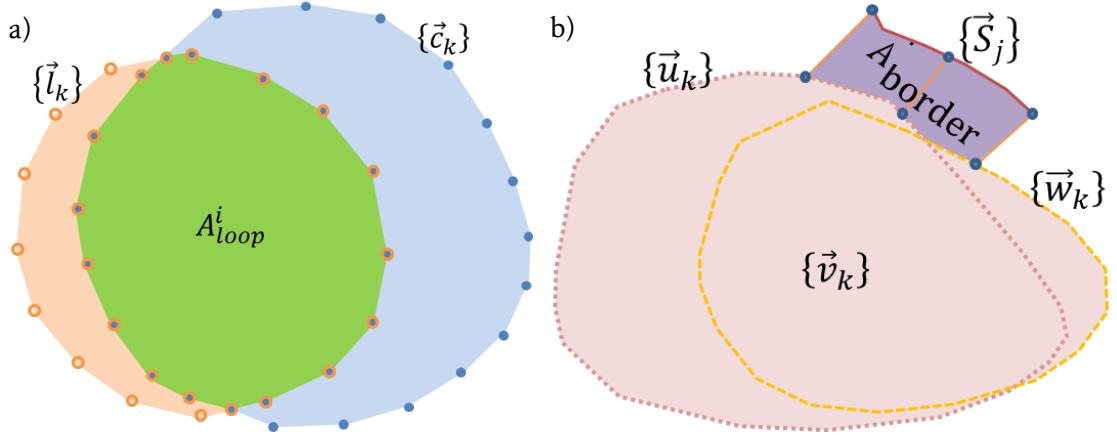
a) Intersection area A_{loop}^i (shaded green, enclosing points shown as concentric circles, blue inside, orange outside) between convex hull of the catheter loop $\{\vec{l}_k\}$ (orange and green shaded areas, enclosed by hollow orange circles) and convex hull of target chamber projection $\{\vec{c}_k\}$ (blue and green shaded areas, enclosed by solid blue circles). b) Separation area A_{border} (shaded light purple) between X-ray cardiac border $\{\vec{S}_j\}$ (red line) and the combined LRV polygon (shaded light pink) defined by points in $\{\vec{v}_k\} = \{\vec{u}_k\} \cap \{\vec{w}_k\}$ (dotted light red and dashed dark yellow closed paths respectively). Endpoints and midpoint of cardiac border and corresponding points on combined LRV polygon marked (blue circles at ends of orange lines).
